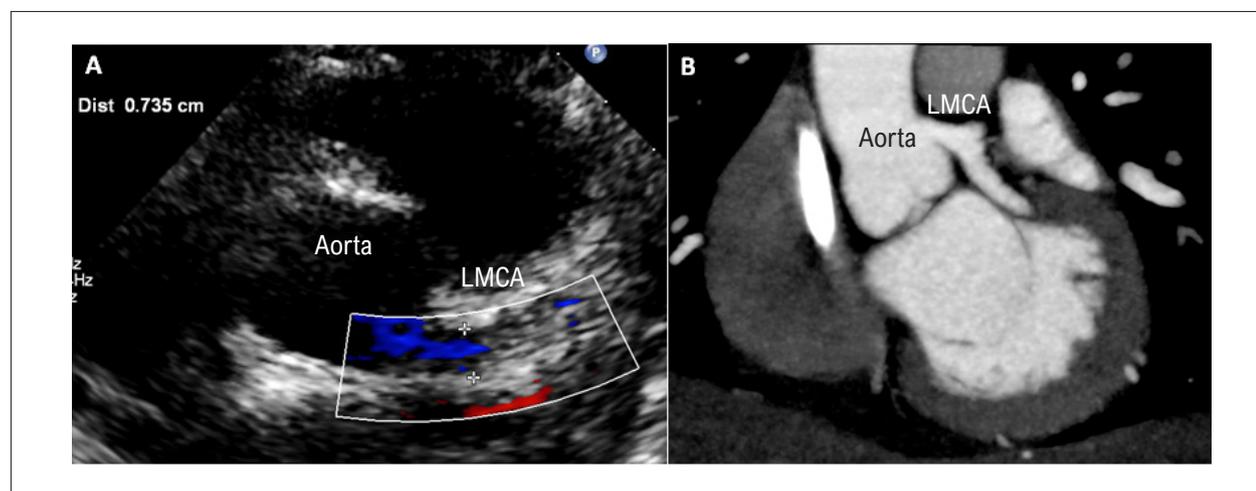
A) Echocardiogram showing dilated left main coronary artery (LMCA) in a 15-year old girl; B) Computed tomography of the same patient.
